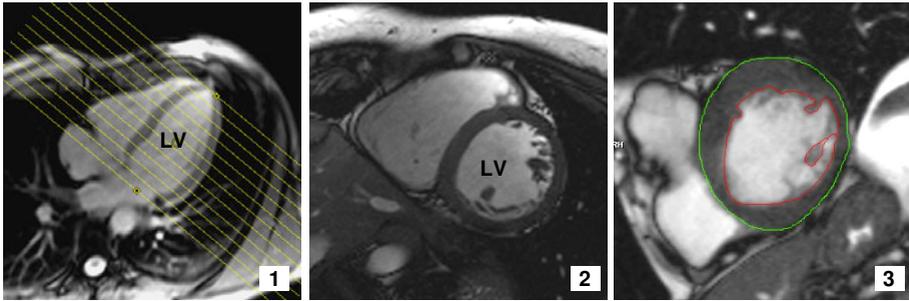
Routine Cardiac MR images: 1) Cine image of long-axis view of the heart (LV = Left Ventricle) showing planned short-axis imaging planes (yellow lines); 2) Mid ventricular short-axis image; 3) Image analysis contours drawn around the inner (red) and outer (green) borders of the LV wall.
